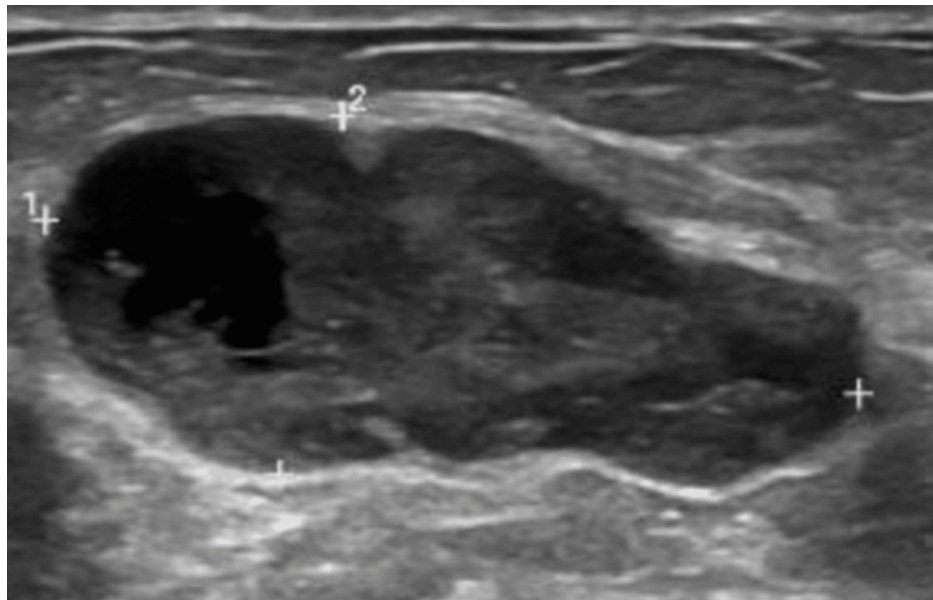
Breast ultrasound of the right breast nodule.
